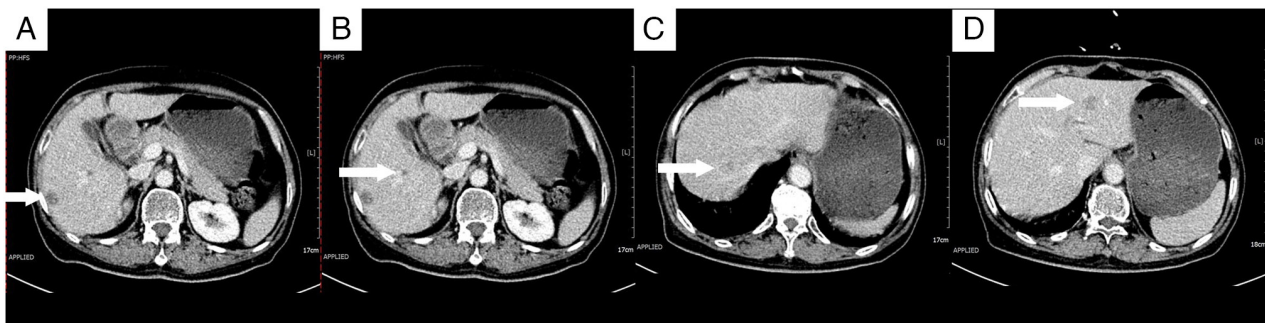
Enhanced computed tomography scans 3 months after surgery. (A) A 14x11-mm lesion beneath the liver capsule in the right lobe (arrow). (B) An 8x7-mm lesion adjacent to the right portal vein (arrow). (C) A 17x14-mm lesion at the apex of the right lobe (arrow). (D) A 15x15-mm lesion in the left lobe (arrow).
